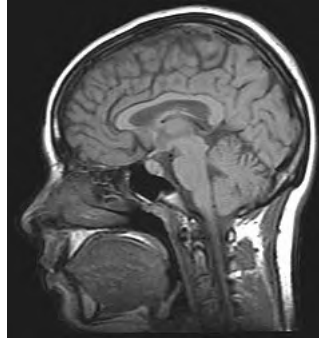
An MRI image of the human brain. [Image obtained from [4]]
